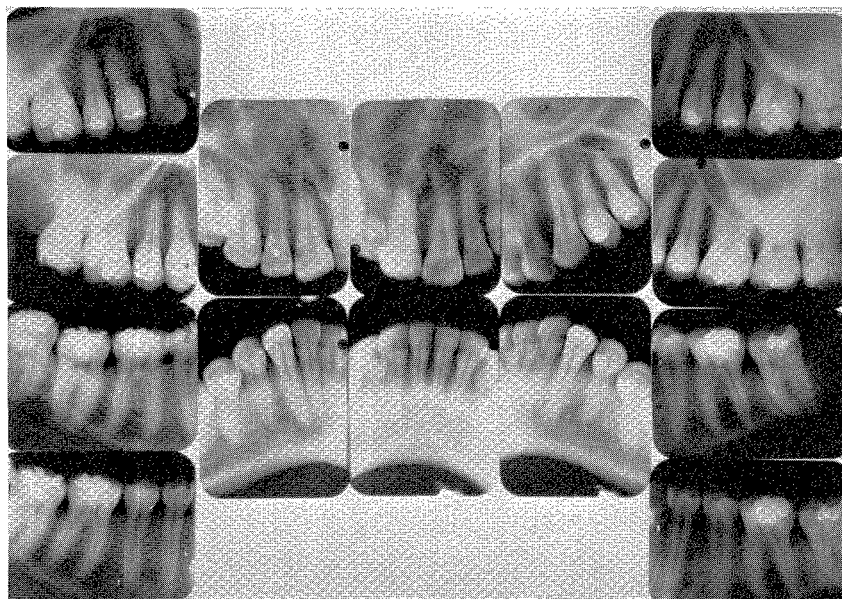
Roentgenograms of the patient shown in Fig. 33 taken in 1933 when she was in her early thirties.
